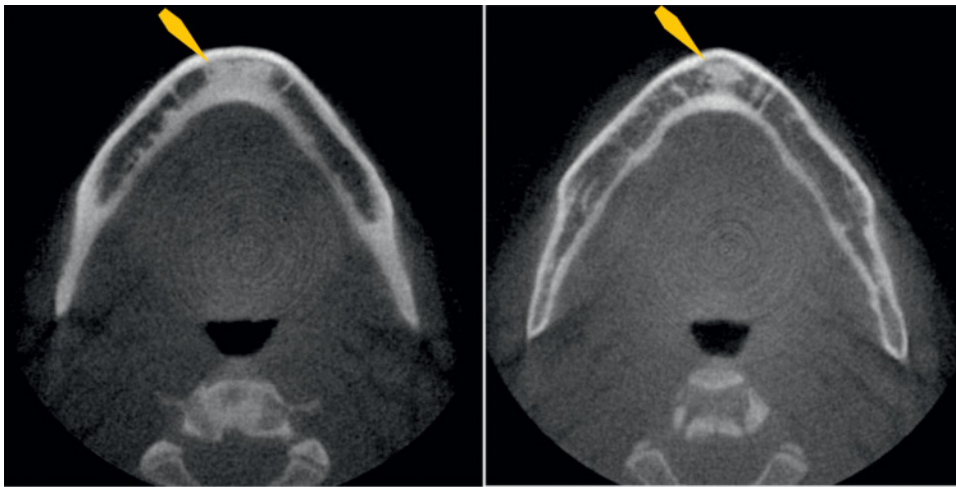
Computed tomography images of idiopathic osteosclerosis (arrows) show a lack of encapsulation and connection with overlying cortex.
